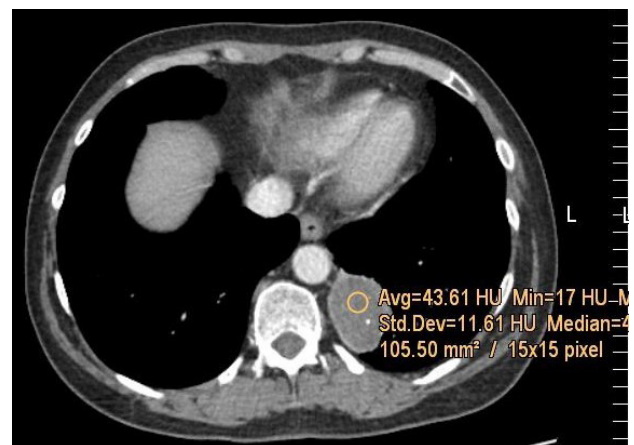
29-year patient's CT axial scan after CE demonstrate (arrow) left paravertebral ill-defined homogeneous cystic lesions with 43 HU attenuation (ROI).
